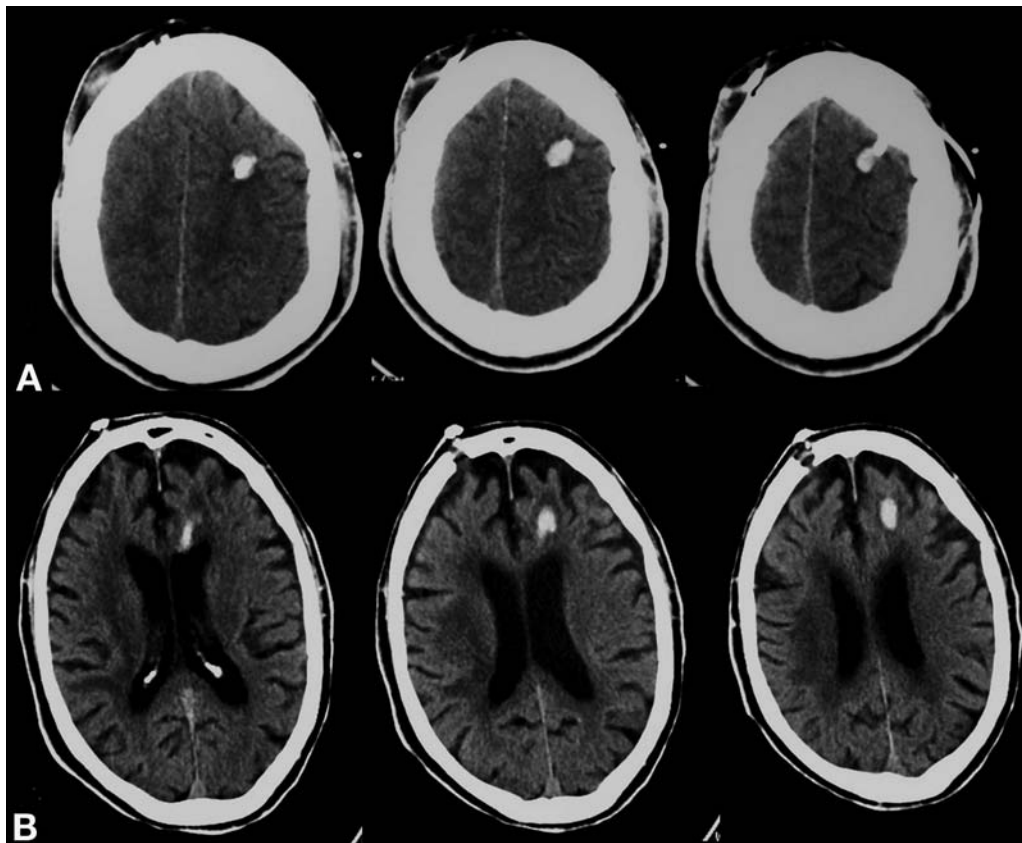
Head CT scans demonstrating *de novo* development of periventriculostomy contusions in two patients (A, patient 6; B, patient 8). Of note, the contusions were contralateral to the intraparenchymal hemorrhage and to the intraclot catheter.
